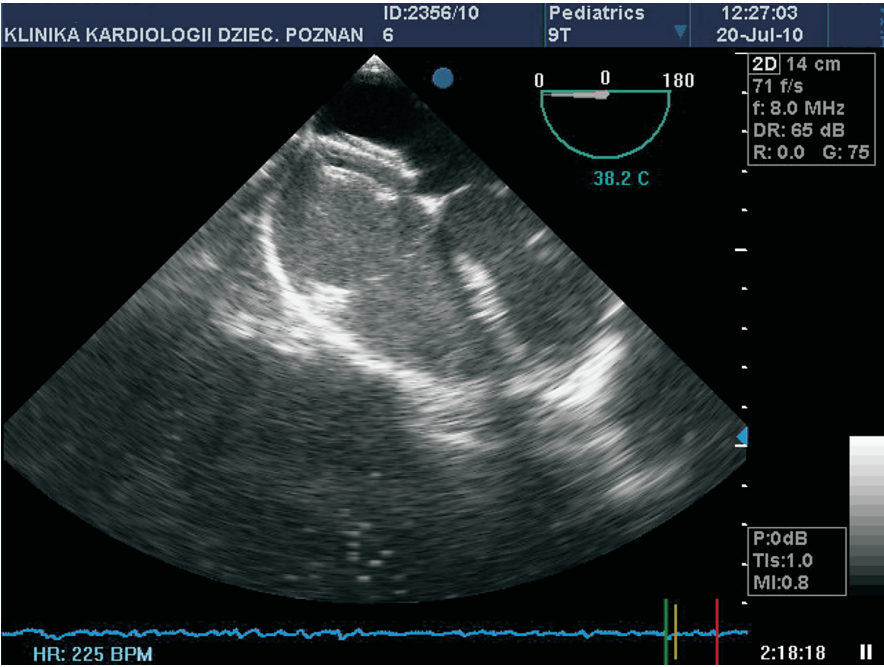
Echocardiography. Ostium secundum atrial septal defect (ASDII) occluded with Amplatzer septal occluder
